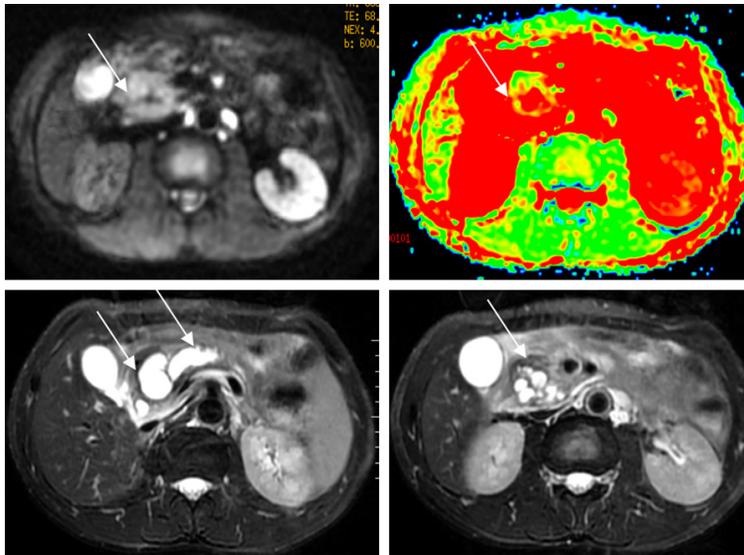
MRI-DWI of pancreatic cancer. The patient had a pancreatic carcinoma of the head of the pancreas, with uneven signal intensity and an unclear boundary. DWI showed high signals, and long T1 and T2 signal masses appeared with the head of the pancreas (white arrow). Note: MRI-DWI: magnetic resonance imaging with diffusion-weighted imaging.
